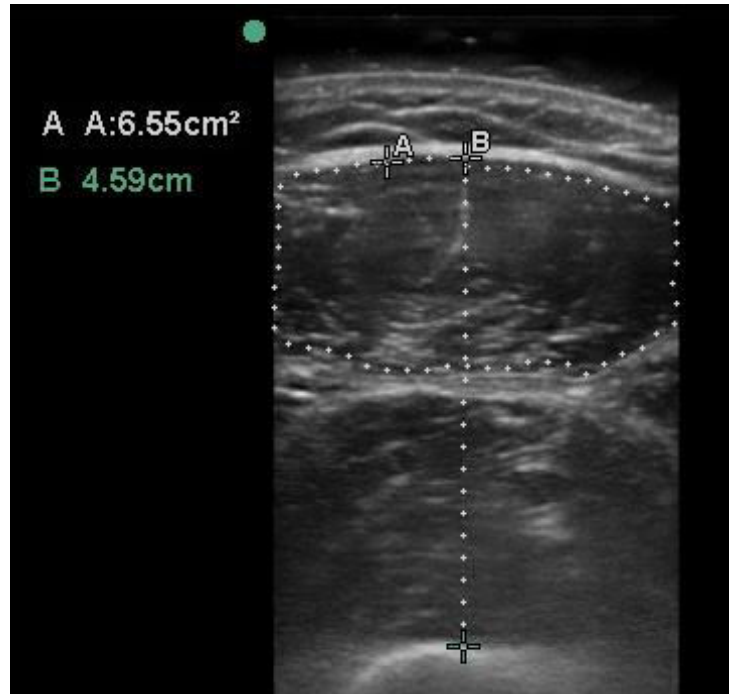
Transverse cross-sectional ultrasound image of the quadriceps muscle layer thickness. Rectus femoris CSA – 6.55 cm²; muscle thickness – 4.59 cm.
